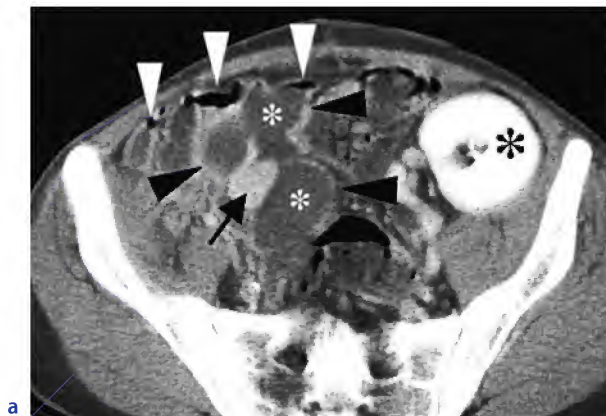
Image from a 38-year-old man obtained 5 weeks after simultaneous pancreas–kidney transplantation with necrotizing graft pancreatitis and subsequent graft extirpation. Contrast-enhanced helical CT displays remnants of contrast-enhanced pancreatic graft (*arrow*) surrounded by fluid and thin-walled membrane (*arrowhead*) representing pseudocyst formation due to necrotizing pancreatitis. Ascites (*white asterisk*) and renal graft (*black asterisk*) are also seen
